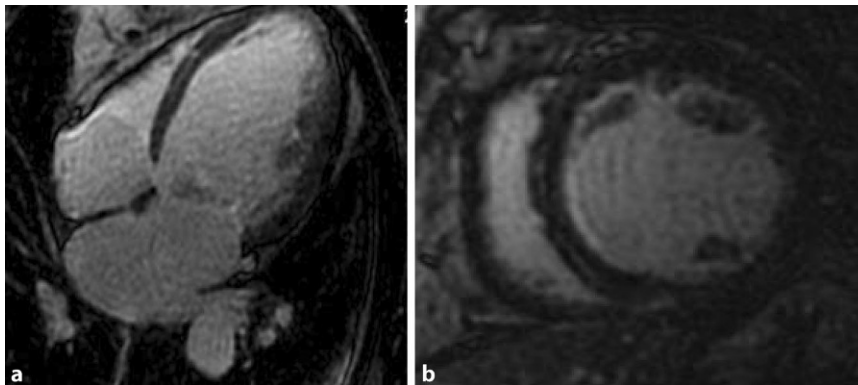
▲ Magnetic resonance imaging: four-chamber (a) and short-axis (b) views in a patient with dilated cardiomyopathy and a midwall area of fibrosis in the interventricular septum
